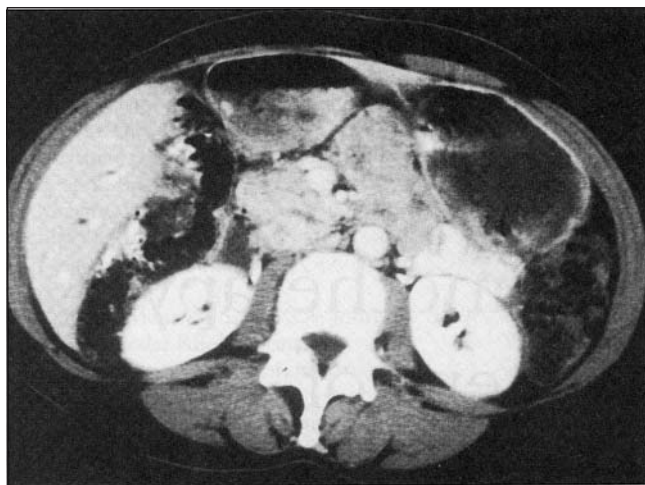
Computed tomography scan of abdomen. A 4x4 cm mass is identified involving the uncinate process with associated pancreatic, common bile duct and intrahepatic duct dilation
